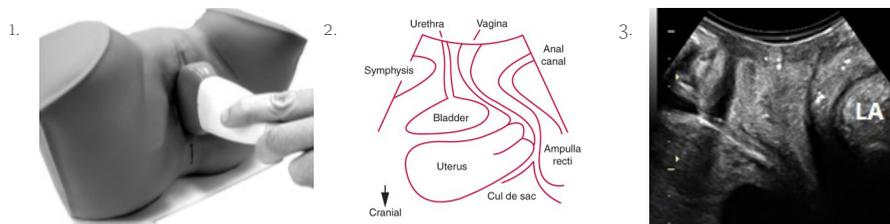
1. Transperineal ultrasound examination with the women in supine position. 2. Two-dimensional view of the mid-sagittal plane of the pelvic floor with the symphysis, urethra, bladder, vagina, uterus and anal canal. 3. LA=the levator ani muscle passing behind the rectum.
